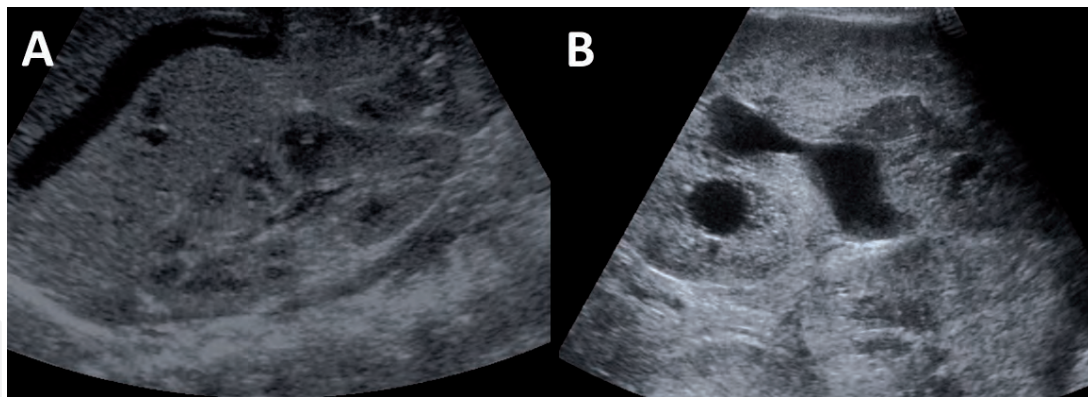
Two patients with acute pyelonephritis (A and B). Although the majority of the acute pyelonephritis has normal ultrasound appearance, in severe form of the disease, kidney enlargement and increased echogenicity of the kidney can be seen. In image (B), collecting duct dilatation is also seen which might be due to obstructive stone in the ureter.
